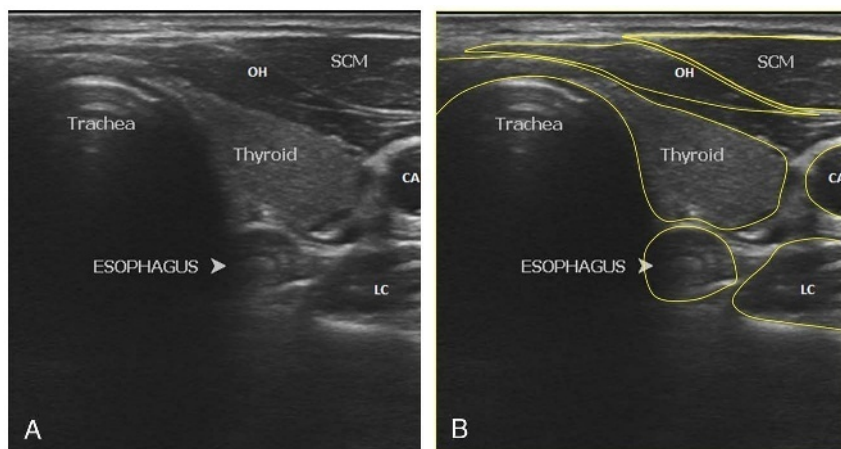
Transverse sonographic image at cervical level of showing trachea, esophagus, thyroid, carotid (CA), longus colli (LC), sternocleidomastoid (SCM), and omohyoid (OH).
